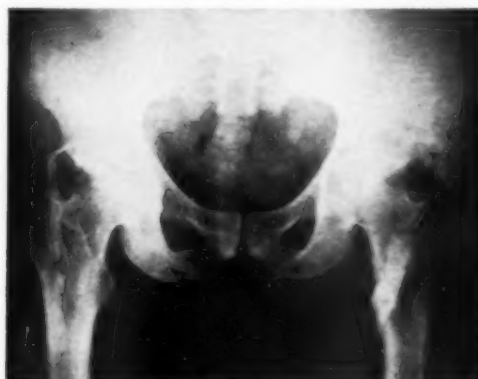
Appearance of pelvis in 1953, ten years after original roentgenograms (Figs. 1-3). There is a large cauliflower-like calcified mass arising from the original operative site at the anterior inferior iliac spine. This had formed within five months after the original operation in 1944. The right hip, where no operative procedure had been done, remains unchanged during the ten-year period.
